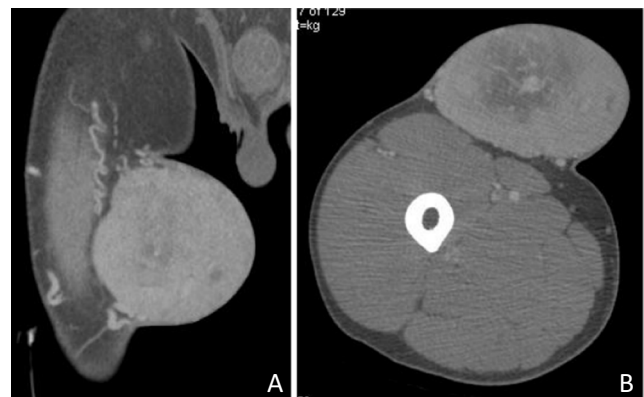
(a) Coronal and (b) axial contrast-enhanced CT of the right thigh
